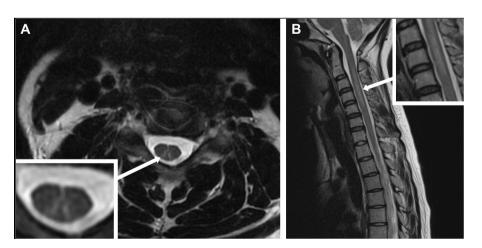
Classical MRI findings in nitrous oxide-induced subacute combined degeneration of the cord. The T2 axial image (A) shows hyperintense signal in the dorsal columns of the cervical spinal cord, creating an 'inverted V' sign. The sagittal image (B) shows the commonly found pattern of hyperintensity extending longitudinally over several cervical spinal segments.
